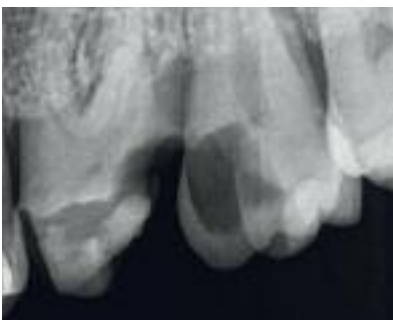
Radiograph after caries removal
